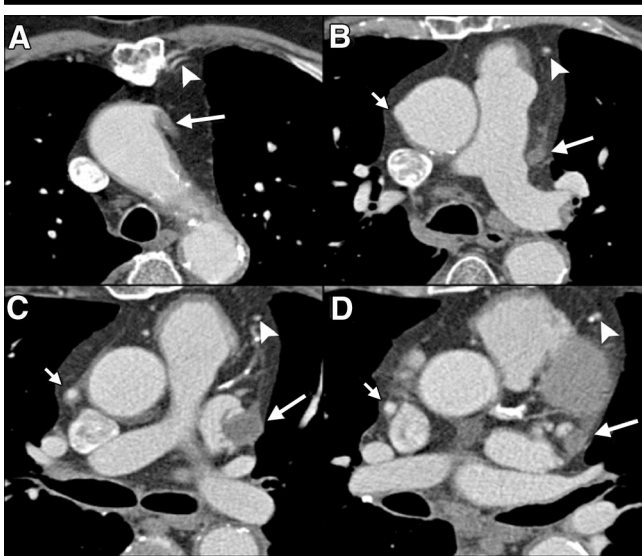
Coronary artery bypass graft status at four-detector row CT. *A–D*, Transverse cranial to caudal base images demonstrate occlusion of a dilated aortocoronary venous graft (large arrows) to the left circumflex coronary artery, while another aortocoronary venous graft (small arrows) communicating with the right coronary artery is patent. Left internal mammary artery graft (arrowheads) to the LAD coronary artery is also patent.
